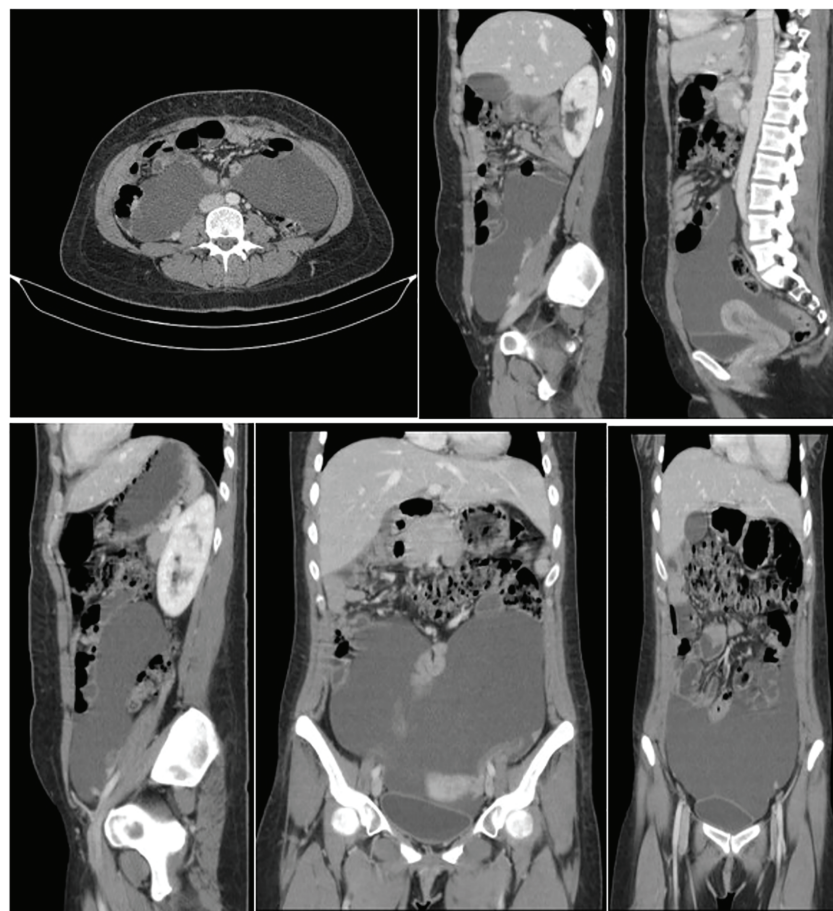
Contrast-enhanced CT scan of the abdomen showing clustered small bowel loops encased within a thin, fibrous membrane, consistent with abdominal cocoon. The sagittal, axial, and coronal thin-cut portovenous phase of a 16-slice CT scan (Siemens, Emotion) revealed that the small bowel loops are enveloped in a layer of peritoneum. The patient has ascites accumulating in the pelvic cavity, not distributed in the abdominal cavity due to the aforementioned peritoneal layer.
